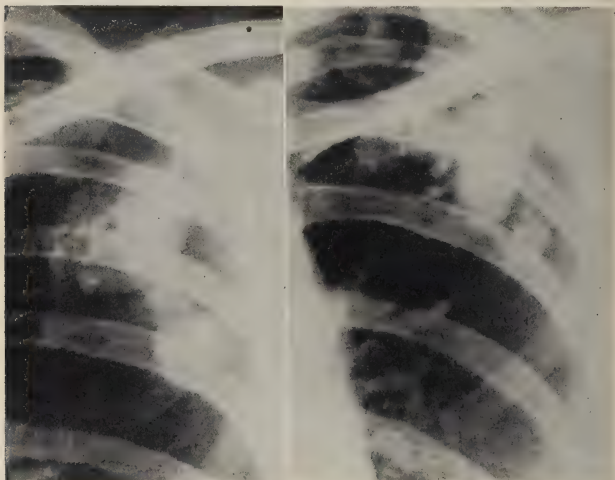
(Case 11). A (Left). Roentgenogram, taken on January 13, 1943, showing a large "dumbbell" deposit in the left upper lobe.
